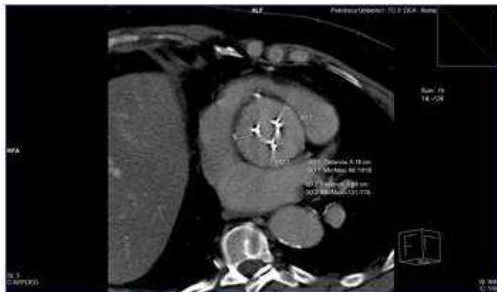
Contrast-Enhanced Computed Tomographic Scan: Short Axial Image Showing the SC Prosthesis and the Aortic Dilatation
